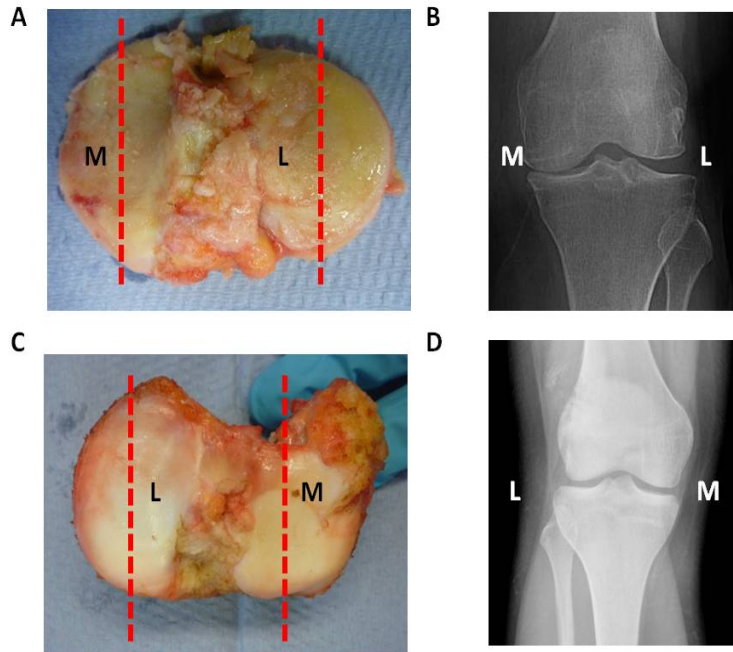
Tibial plateau post-operative photos and pre-operative radiographs [A] OA photo; [B] OA radiograph; [C] Photo of non-OA; [D] Radiograph of a non-OA knee. Red dashed lines indicate the plane the pQCT measurements were taken.
